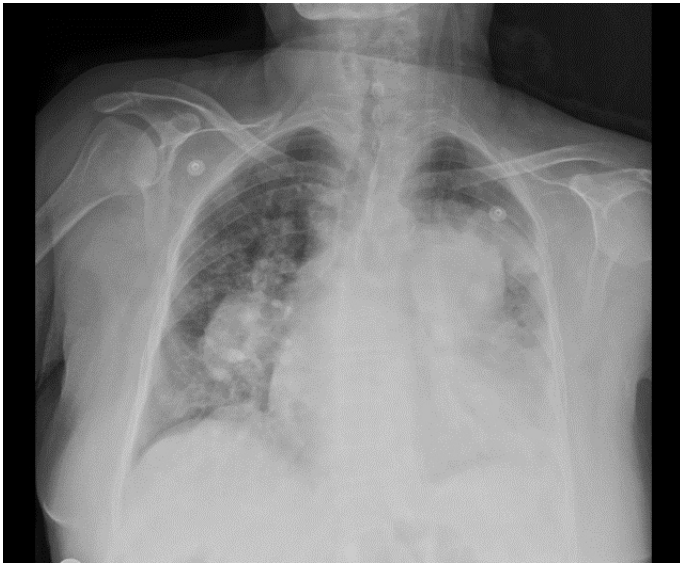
Antero-posterior chest radiography showed enlargement of the right hilum and increased density in the left middle and lower zones.
